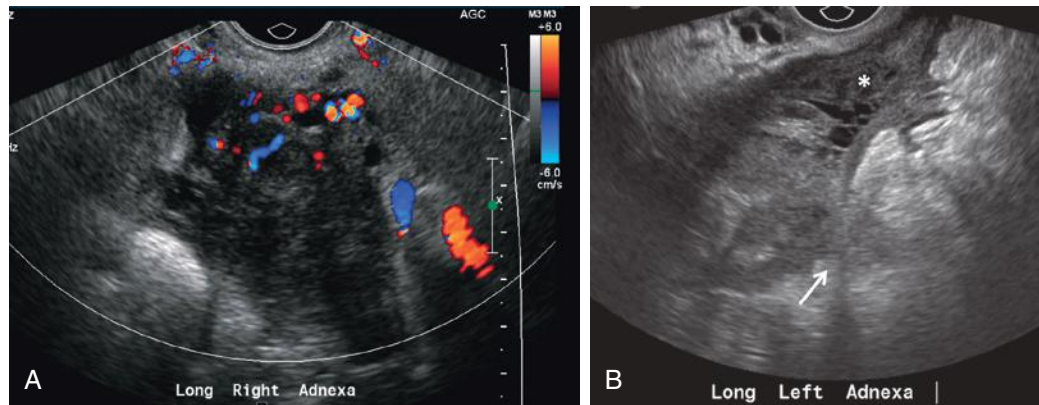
Thirty-year-old woman from southeast Asia presenting with 9 months of unexplained weight loss and pelvic pain. Color Doppler image of the right adnexa (A) and gray-scale image of the left adnexa (B) demonstrate bilateral hyperemic complex adnexal masses. Note surrounding complex free fluid, best seen in B (*) and infiltration of adjacent pelvic fat (arrow in B). Neither fallopian tube or ovary could be discretely identified. Whereas findings are nonspecific and consistent with bilateral tubo-ovarian abscesses, the clinical presentation is atypical for pelvic inflammatory disease because the patient was afebrile and there was no vaginal discharge. CT scan (not shown) demonstrated omental thickening, and biopsy was positive for tuberculosis. CXR (not shown) also demonstrated findings suspicious for tuberculosis. The adnexal masses slowly resolved with anti-TB therapy. (Images courtesy Dr. Manjiri Dighe, University of Washington Medical Center, Seattle, Washington.)
